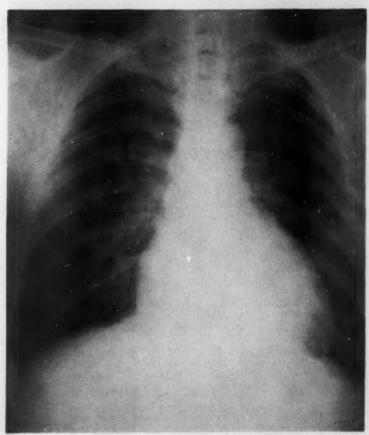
Case 2. Chest x-ray 10 months after therapy with amphotericin. Note clearing of miliary process but increase in cardiomegaly.
